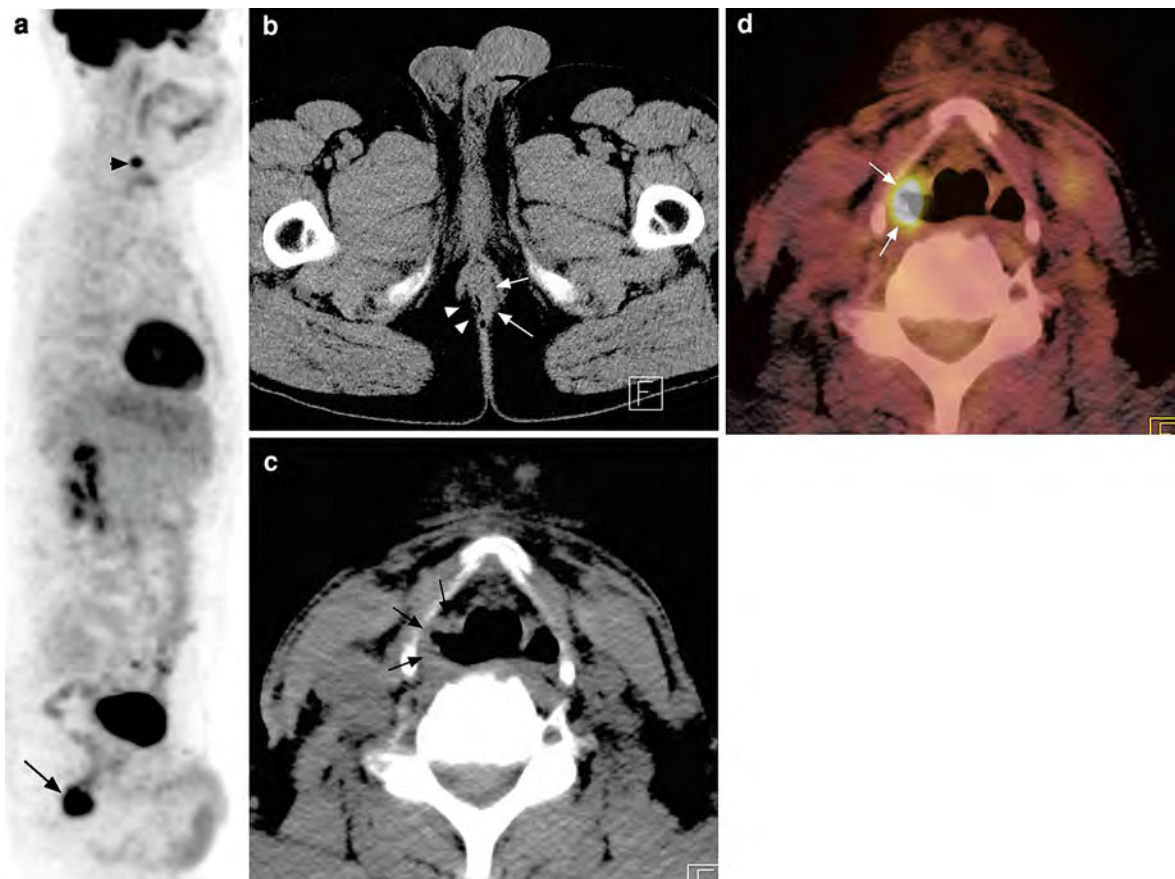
Whole body PET image displayed in sagittal plane (a) shows two areas of marked FDG uptake: very small in the mid neck (arrowhead in a) and a larger one at the rectoanal junction (arrow in a). The axial CT image (b) through the rectoanal junction confirms an infiltrating lesion on the left (arrows in b) with marked infiltration of the perianal fat planes when compared to
